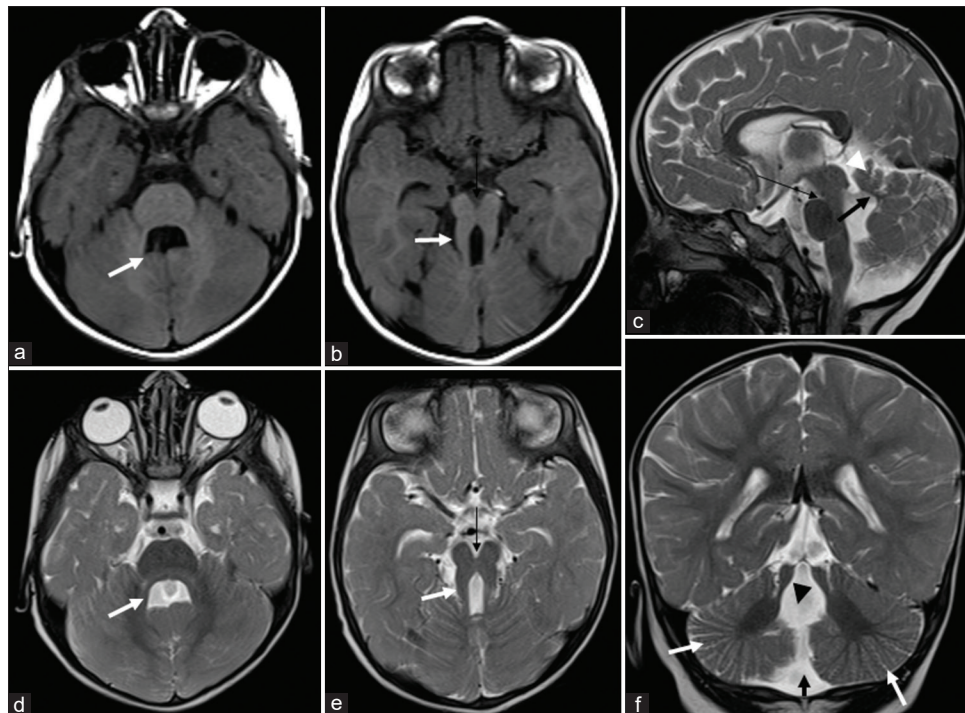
Magnetic resonance imaging of the brain of a child. T1-weighted (a, b) and T2-weighted (d, e) axial sequences show the typical “batwing” shaped fourth ventricle (arrow) (a, d) and elongated, parallel, thickened, and horizontally oriented superior cerebellar peduncles (white arrow) with a deepened interpeduncular fossa (black arrow) (b, e) suggestive of “molar tooth sign” of the midbrain. T2-weighted (c) sagittal sequence shows enlarged and distorted fourth ventricle with a rostral shifting of the fastigium (thick black arrow), vermian hypoplasia (arrowhead), and deepened interpeduncular fossa (thin black arrow). T2-weighted (f) coronal sequence demonstrates retrocerebellar CSF collection (black arrow), enlarged and distorted fourth ventricle (arrowhead), and abnormal foliation and fissuration of bilateral cerebellar hemisphere (white arrow).
